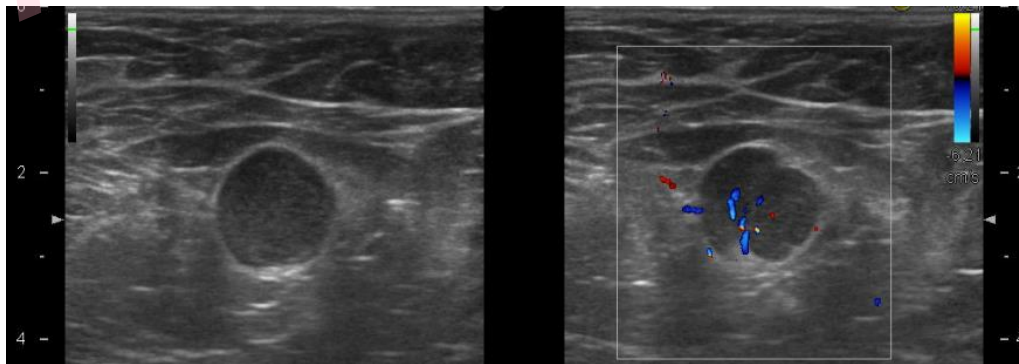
Ultrasound images show axillary lymph nodes enlargement, with the thick cortex.
